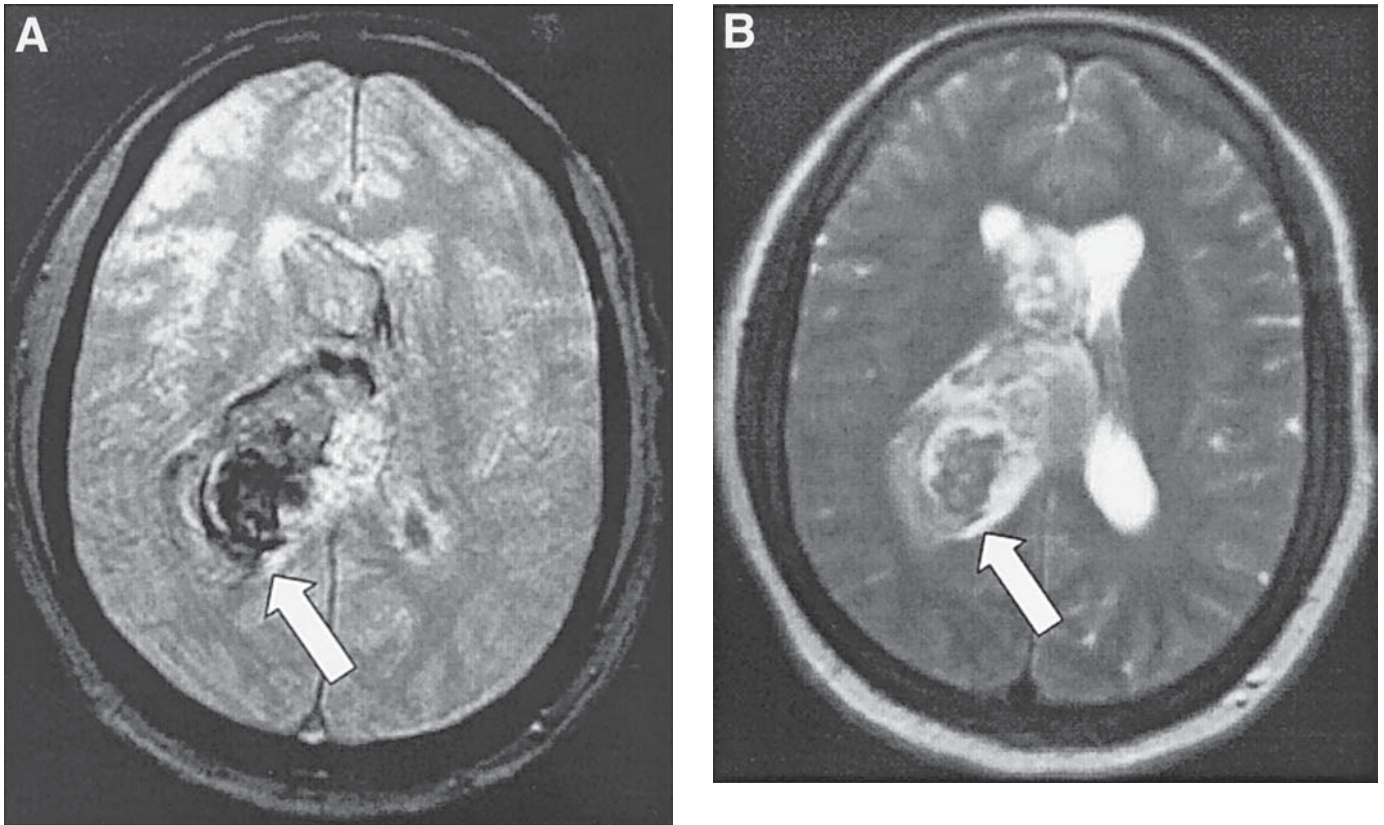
Glioblastoma multiforme with intratumoral hemorrhage. A 51-yr-old female with left hemiparesis and global aphasia. (A) MRI gradient refocused echo sequence shows large areas of hypointensity reflecting intratumoral hemorrhage (white arrows); (B) T2-weighted MR sequence with mixed signal intensity (white arrow).
